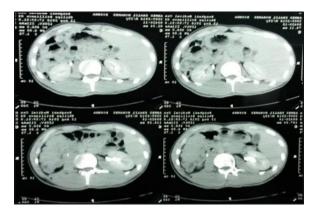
CT scan abdomen shows no free peritoneal fluid, liver and both kidneys were normal, no extravasation of contrast.
